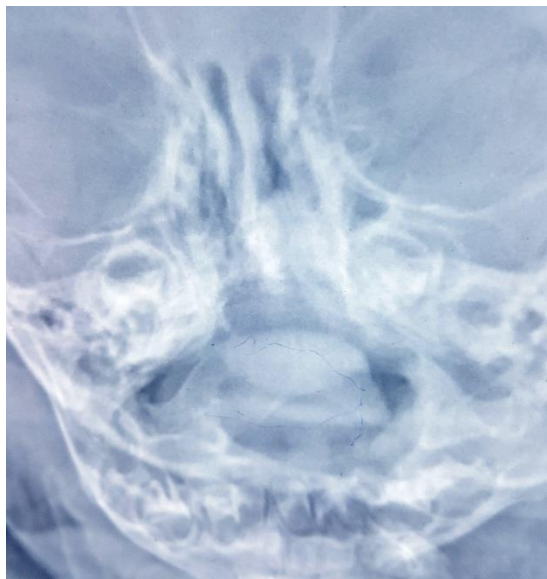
Postoperative radiograph with no evidence of lesion.
